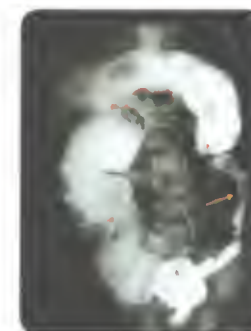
Barium enema radiograph showing aganglionic segment (yellow arrow) and megacolon (green arrow) in Hirschsprung's disease
